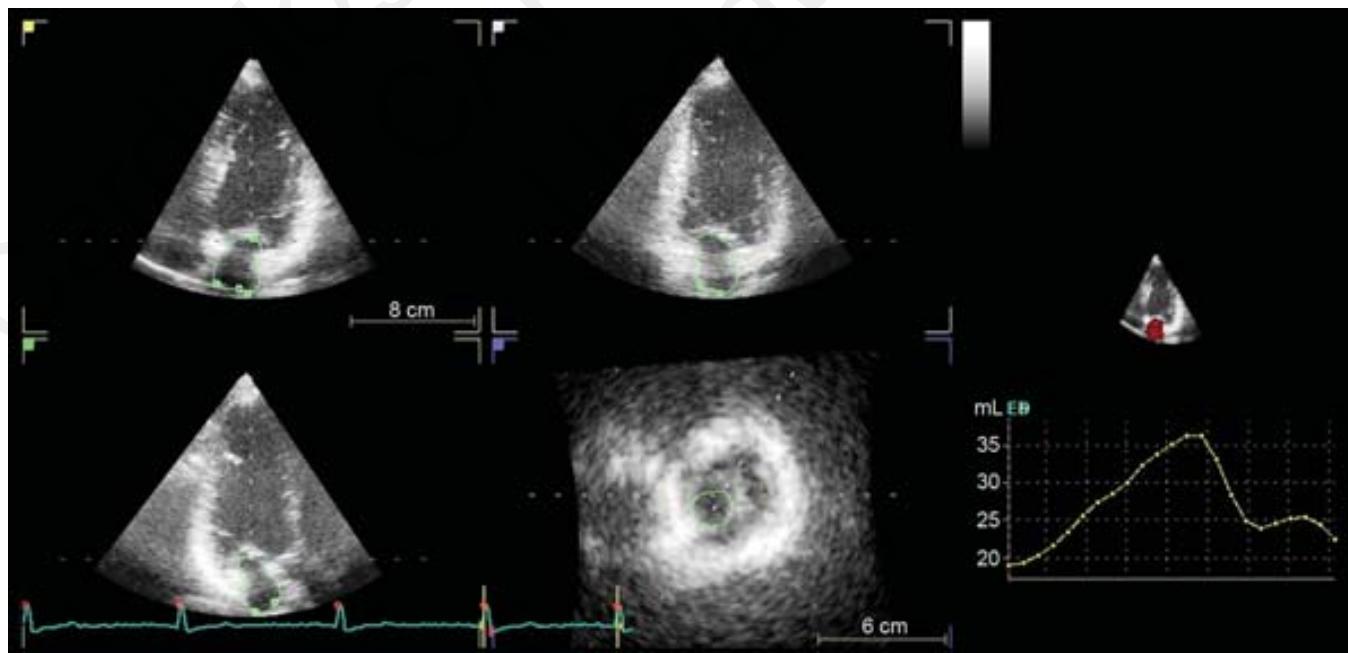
Use of three-dimensional echocardiography for estimation of left atrial volume. Same principle is used as for left ventricular volume.
